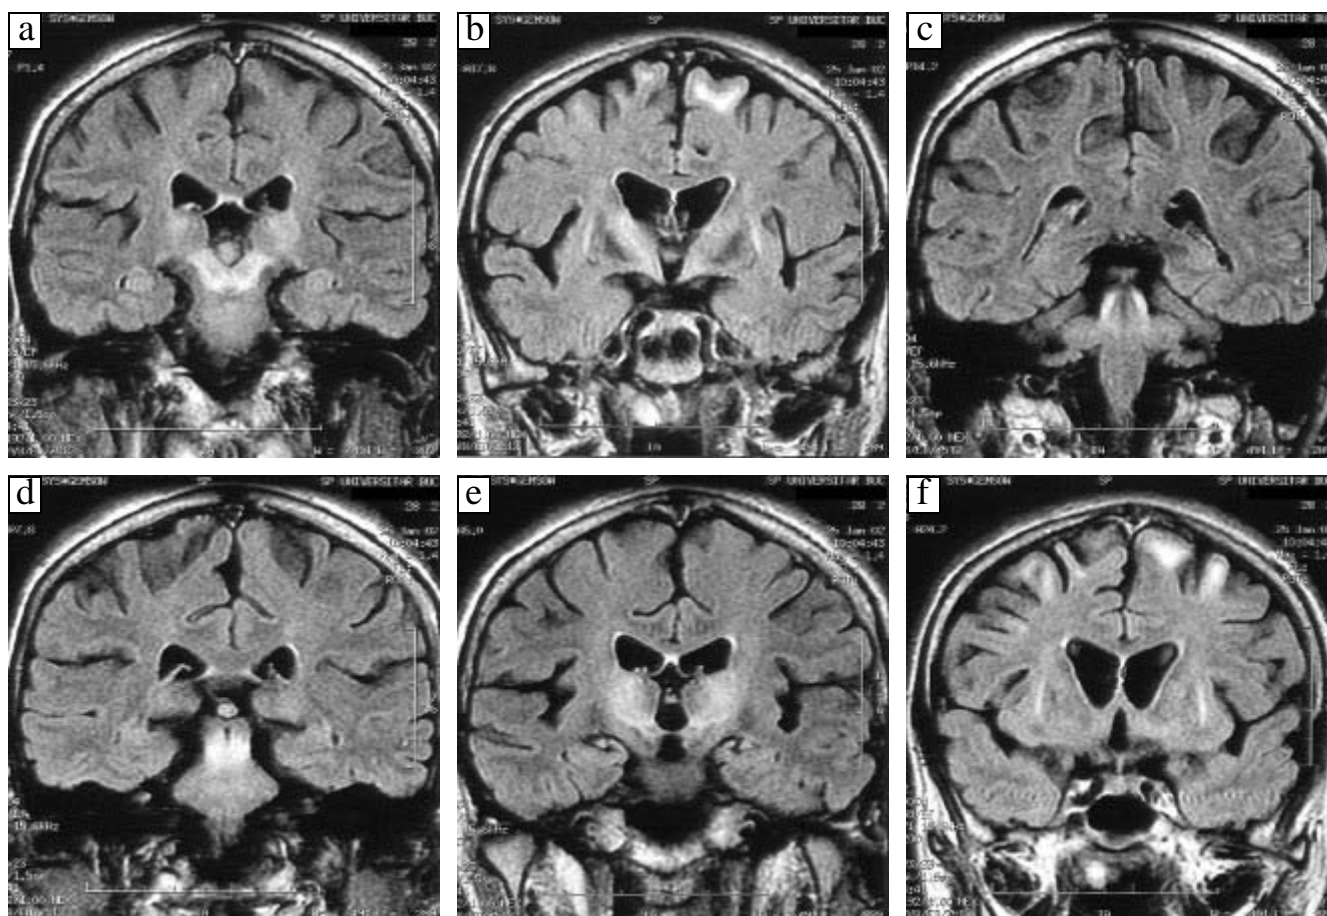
Coronal FLAIR Sequences on the brain of a patient with Wilson disease.
